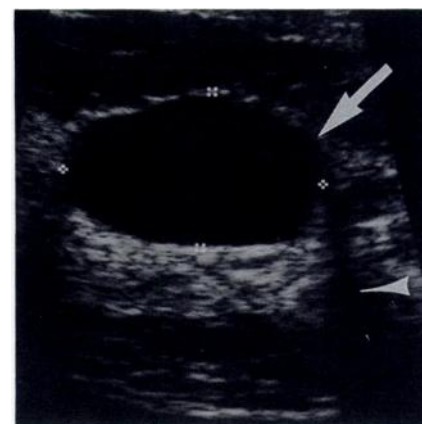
Sonogram of typical cyst. Oval mass (arrow) has well-defined anterior and posterior borders, anechoic interior, and enhanced through-transmission of sound distally. Arrowhead indicates refractive shadows distal to lateral wall of cyst.
